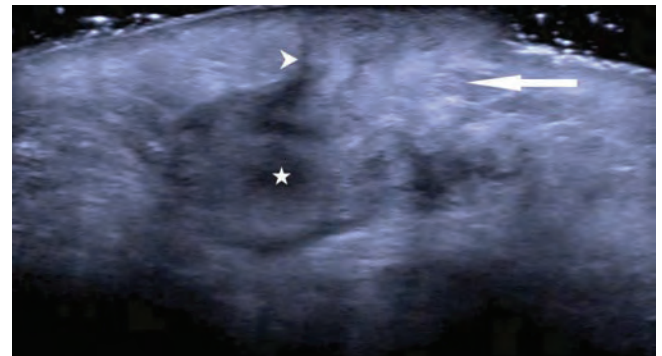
Ultrasound scan over the skin nodule showing loss of skin and soft tissue planes, with echogenic thickened subcutaneous fat (arrow). An underlying 21mm ovoid cystic collection containing mobile internal echoes (star) with posterior acoustic enhancement and perilesional echogenicity is located 25mm deep from the nodule's skin surface. A thin hypoechoic track (arrowhead) communicating from the anterior aspect of the collection to the skin surface represents a sinus track, akin to a volcanic vent rising to the top. The sonographic area encompassing the inflamed, oedematous tissue is 35mm wide.
